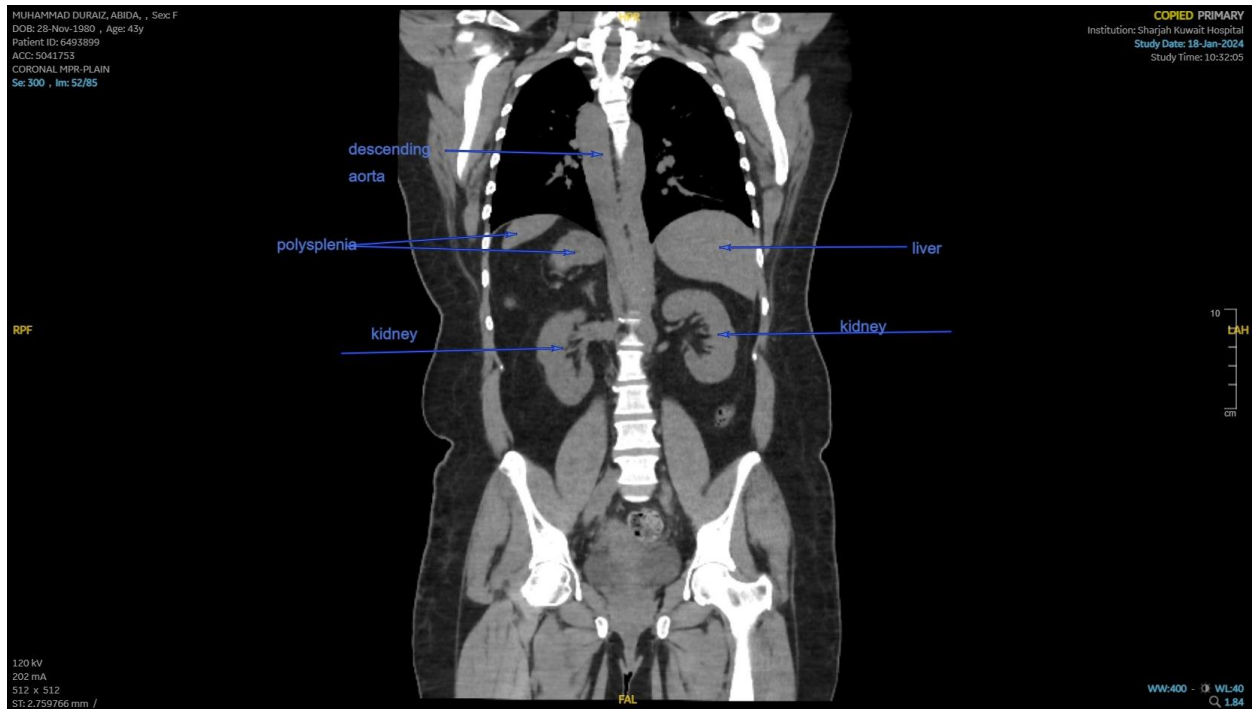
Dextrocardia via CT abd -chest
